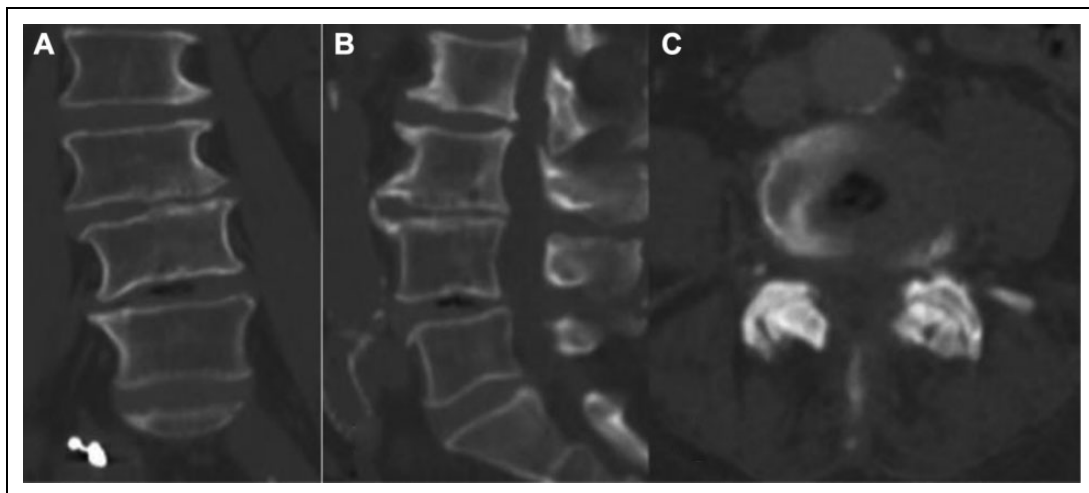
Minimal vacuum phenomenon at L4-L5 lumbar spine, note the central air distribution in coronal (A), sagittal (B), and axial (C) computed tomography scan.
